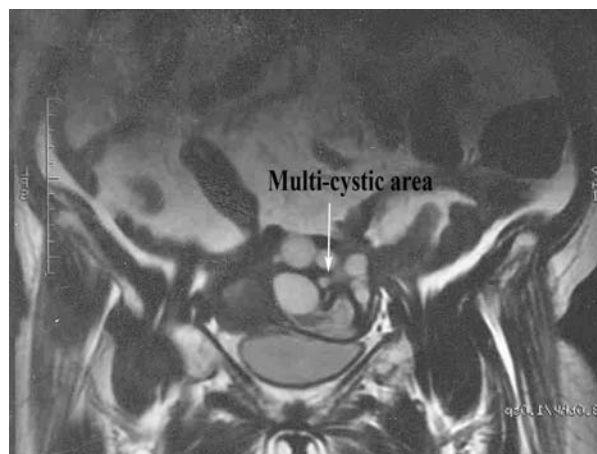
A cystic area and enlarged uterus which was shown by MRI.
